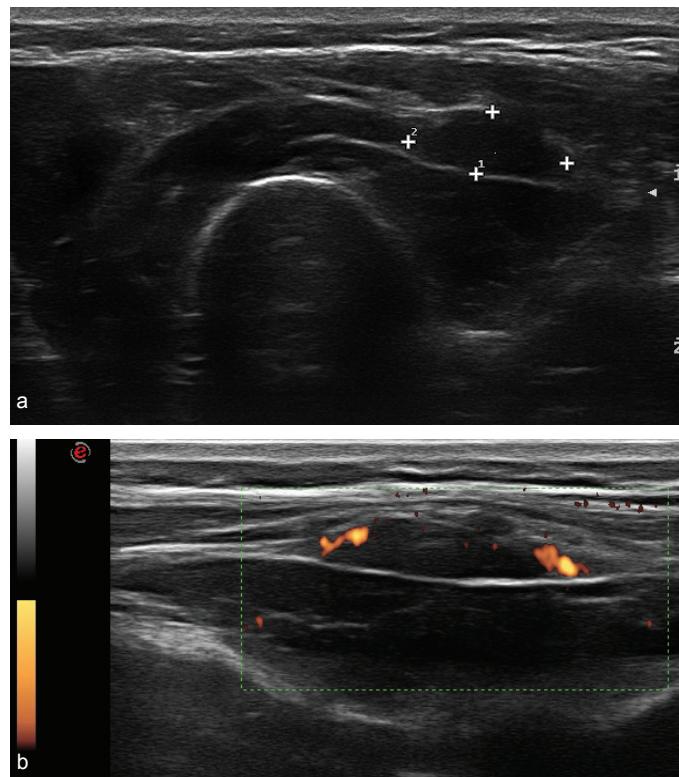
a) Short-axis view of the enlarged posterior interosseous nerve within the supinator muscle, b) Long-axis view of the enlarged posterior interosseous nerve with vascularity on power Doppler.
